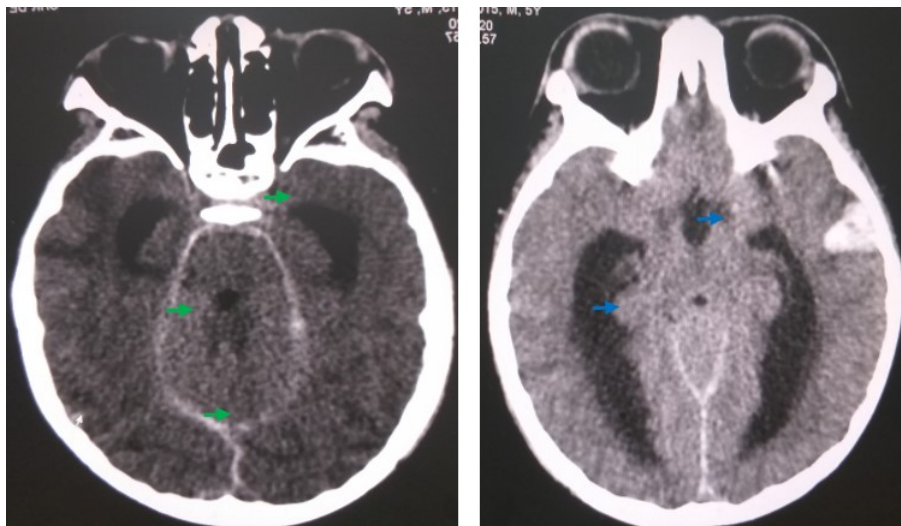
CT axial section a: Meningeal hemorrhage (green arrow) b: Early hydrocephalus (blue arrow)
